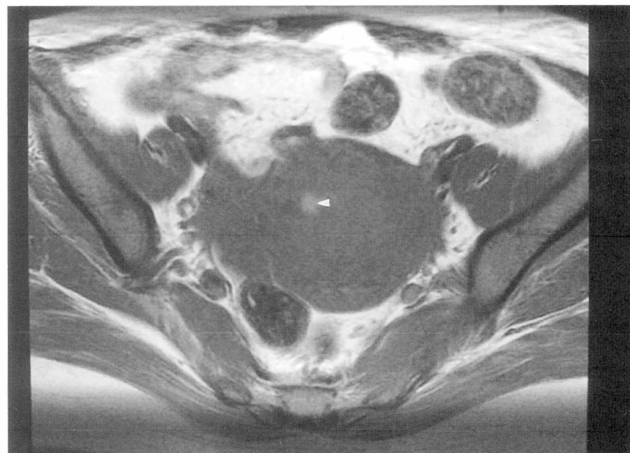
Initial ultrasound and MRI of the pelvis. A. Trans-abdominal ultrasound shows an isoechoic solid mass filling the uterine cavity. B. Color Doppler ultrasound shows high flow resistance within intralesional arteries (P.I. = 1.58, R.I. = 0.771). C. Fast spin-echo sagittal T2-weighted MRI (TR 4200/TE 123) shows a slightly hyperintense signal mass filling the uterine cavity, with a focal breakthrough into the myometrium (arrow). D. Axial T1-weighted MRI shows that the mass has similar signal intensity to the myometrium, and the focal high-signal-intensity area on T1-weighted image (arrowhead) also remains intense on the T2-weighted image, correlating with focal hemorrhage. E. Sagittal gadolinium-enhanced T1-weighted MRI with fat suppression shows heterogeneous enhancement of the tumor (arrows), but the enhancement is less than that of the myometrium.
